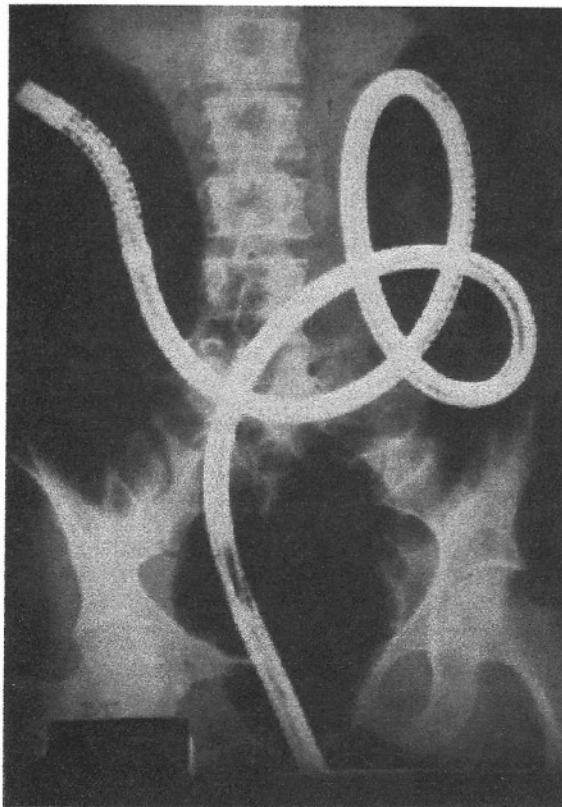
X-ray plate showing the undesirable loops that can form in the colonoscope during colonoscopy [1.14]
